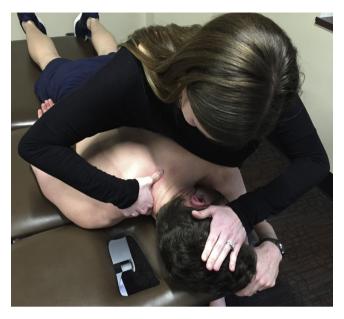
Cervicothoracic (CT) junction lateral break manipulation in prone.
